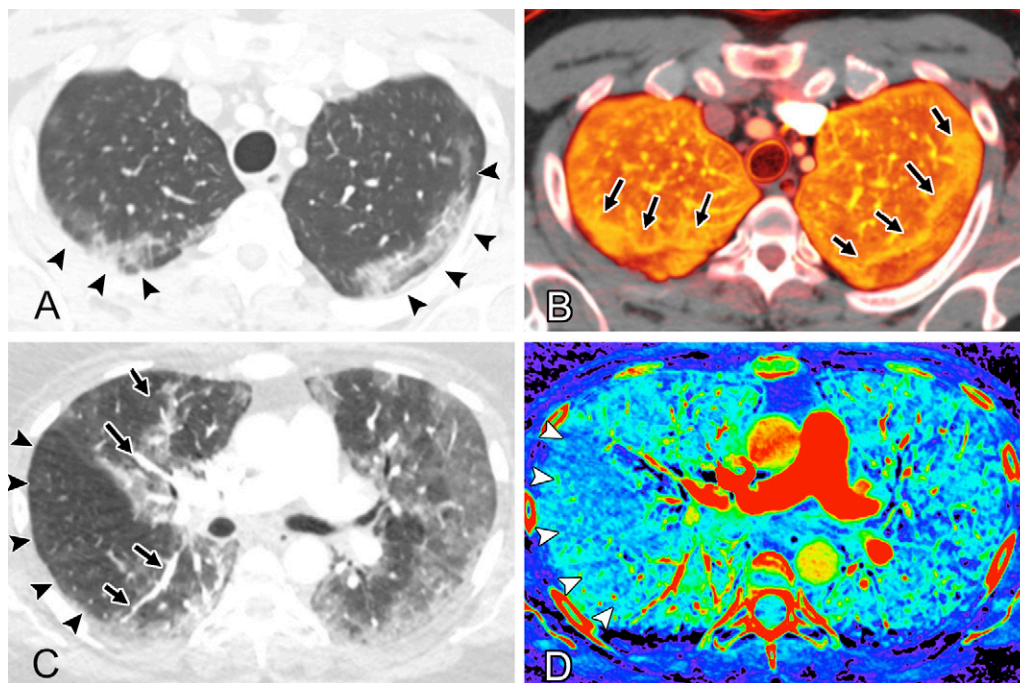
A, B, Images in a 41-year-old man who presented to the emergency department with acute shortness of breath and underwent CT pulmonary angiography for concern for pulmonary embolism. Patient tested positive for coronavirus disease 2019 infection. A, Peripheral ground-glass opacities are present in the posterior upper lobes (arrowheads); regional dilatation of vessels is noted in adjacent upper lobes. B, Pulmonary blood volume image at the same level shows peripheral perfusion defects corresponding to the opacities, with surrounding halos of increased perfusion (arrows). C, D, Images in a 57-year-old woman who presented with 7 days of fever, malaise, chills, cough, and increasing shortness of breath. On day 3 of admission, patient developed increasing oxygen requirement and elevated d-dimer level. C, CT scan of the upper lungs at lung windows shows ground-glass opacities in the central and peripheral upper lungs bilaterally, with regional low attenuation of a portion of the right upper lobe and superior segment of the right lower lobe (arrowheads). Vessels within the low attenuation region are diminutive in a regional pattern, while vessels in the areas of ground-glass opacity are dilated (arrows). D, Corresponding iodine map image shows regional decreased perfusion to the right lung (white arrowheads) and increased perfusion to the areas of ground-glass opacity, while there is also heterogeneous perfusion of the left upper lobe.
